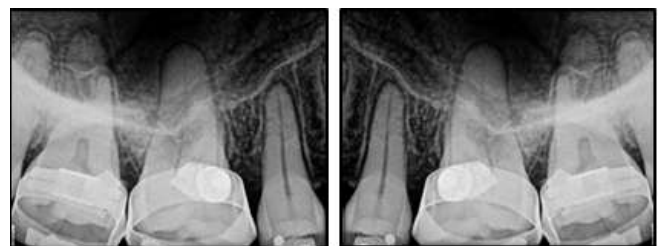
No evidence of root resorption was appreciated radiographically on RVG.
